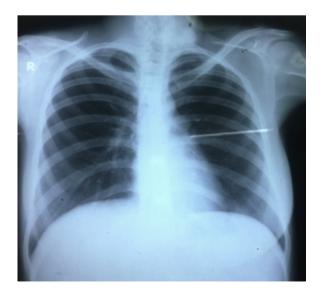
Chest radiograph PA view showing no abnormality.
